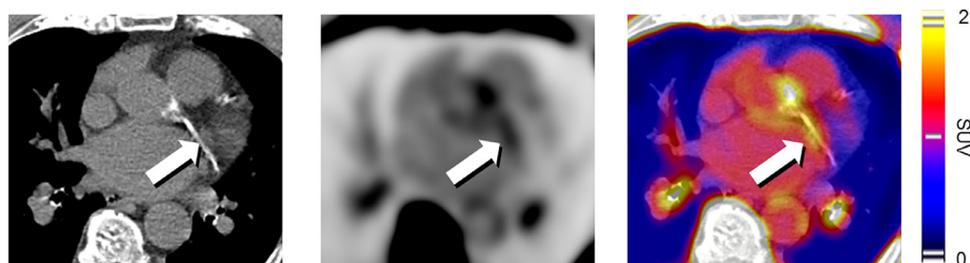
Axial CT (left), PET (middle), and fused (right) images of a NaF-PET/CT study in an 88-year-old male with left ventricular hypertrophy and aortic stenosis investigated for cardiac amyloidosis. Although the study showed no evidence of cardiac amyloidosis, increased NaF uptake is seen in the left main artery (arrows), corresponding to coronary calcification seen on CT, identifying potential high risk coronary lesions.
